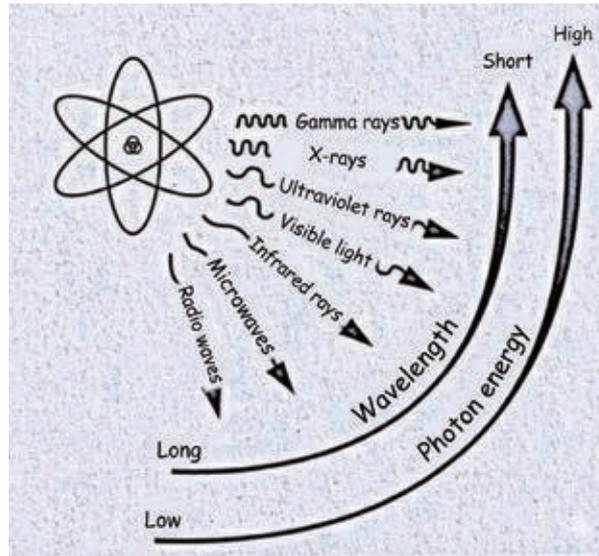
Relationship between Wavelength and Energy of Electromagnetic Waves (from X-ray and CT Examination: The Risks of Medical Radiation Exposure<sup>3</sup>)
